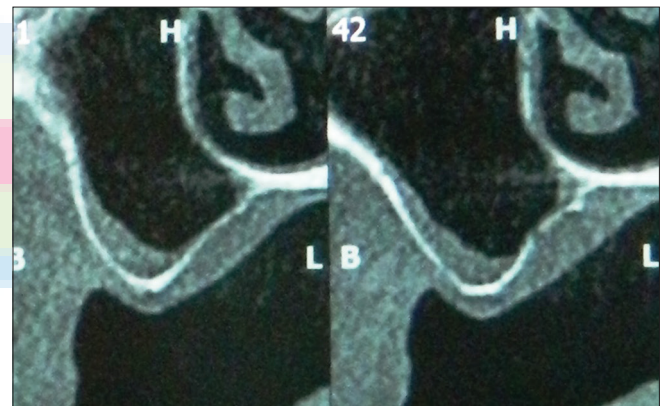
Cone-beam computed tomography showing sinus pneumatization on both the sides
